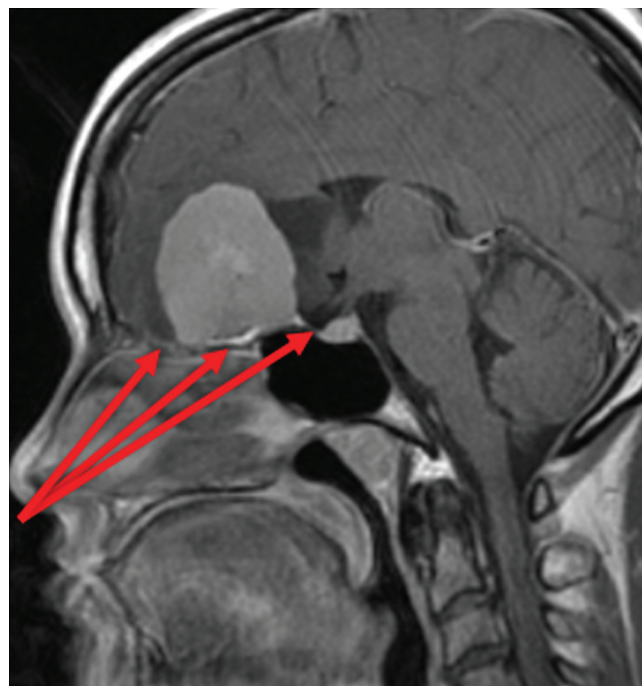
Case 1. Preoperative sagittal T1-weighted Gd-enhanced MR image demonstrating a large olfactory groove meningioma that extends from the cribriform plate anteriorly to the tuberculum sellae posteriorly. The red arrows indicate the range of exposure that can be obtained with an endoscopic endonasal approach to the entire ventral skull base from the crista galli to the tuberculum sellae.
